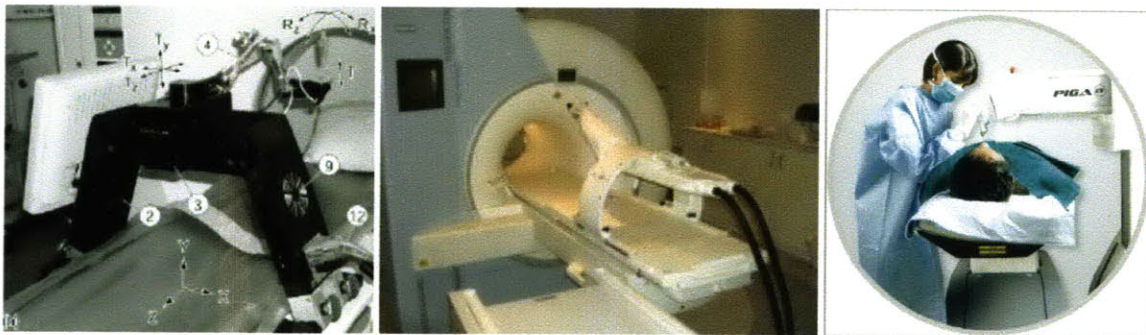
CT scanner and floor mounted robot systems. Left; the Acubot from John's Hopkins University [source (55)]. Middle; Innomotion pneumatic robot from Innomedic [source (53)]. Right; PIGA floor mounted robot from Perfint in India [source <http://www.perfintech.com>]. While these systems can improve the precision of needle placement, their disadvantages include a large capital cost, restrictive patient access and a safety risk to patients should inadvertent patient movement occur. Due to their large structural loops, these systems are required to be very stiff, thus making them expensive.
